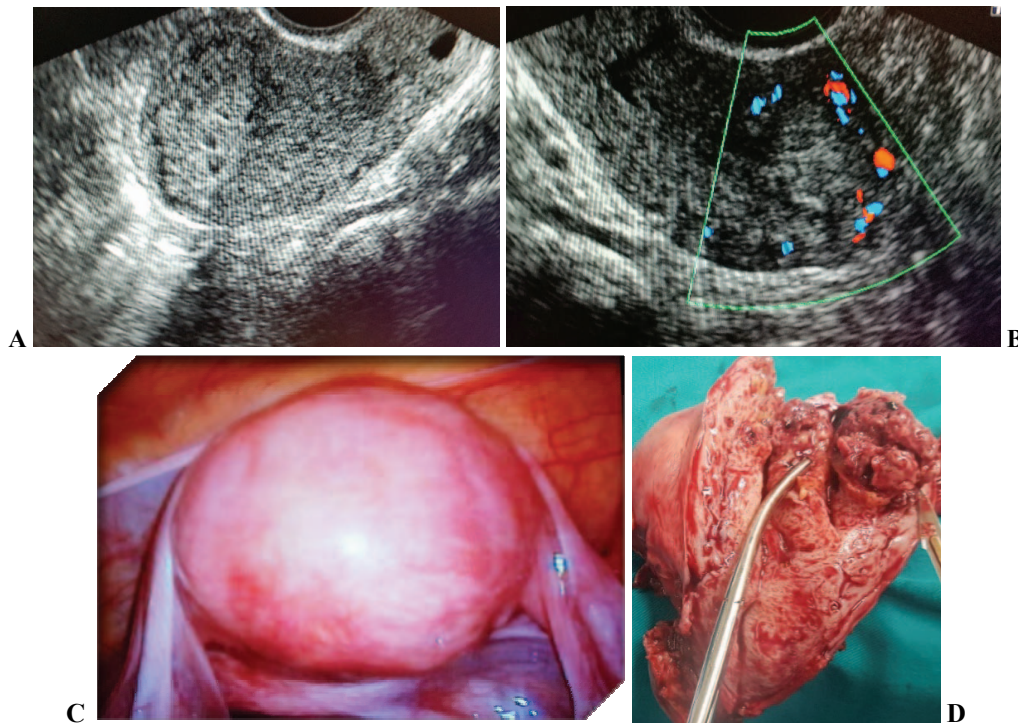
A) Uterus: transverse section; B) Gestational trophoblastic neoplasms (GTN) - Color Doppler flow; C) Uterus: laparoscopic view; D) Dissected uterus with GTN.
